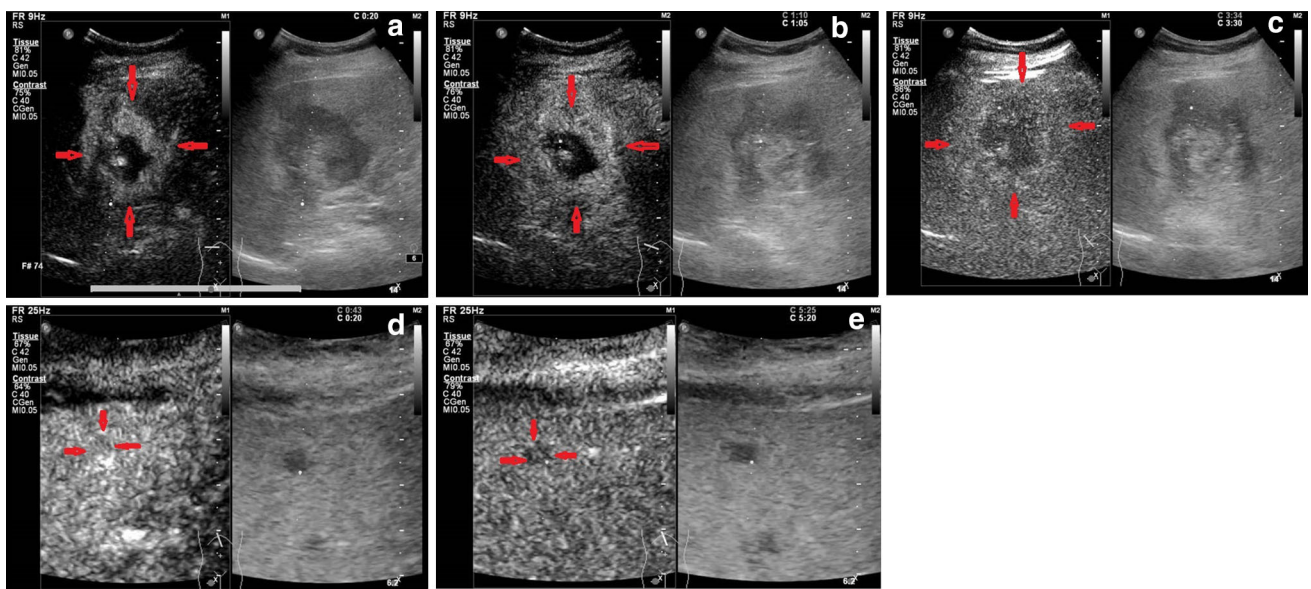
Contrast-enhanced ultrasound images. a The larger mass was hyperenhanced like an irregular bright, thick ring in the arterial phase. b The peripheral enhancement of the larger mass washed out gradually, appearing slightly hyperenhanced in the portal phase. c In
